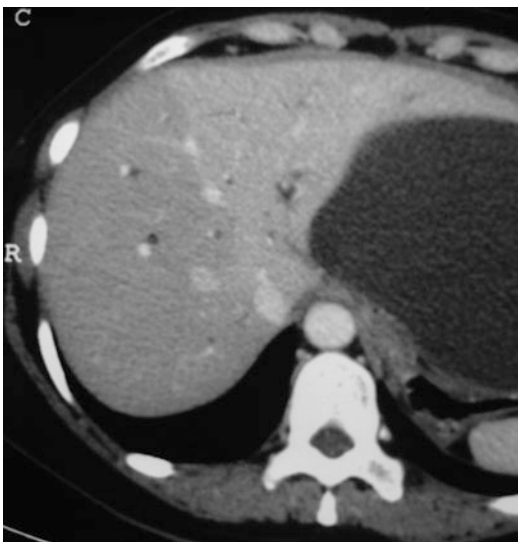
Perfusion abnormality of right lobe of liver on contrast enhanced computed tomography suggests a vascular injury
